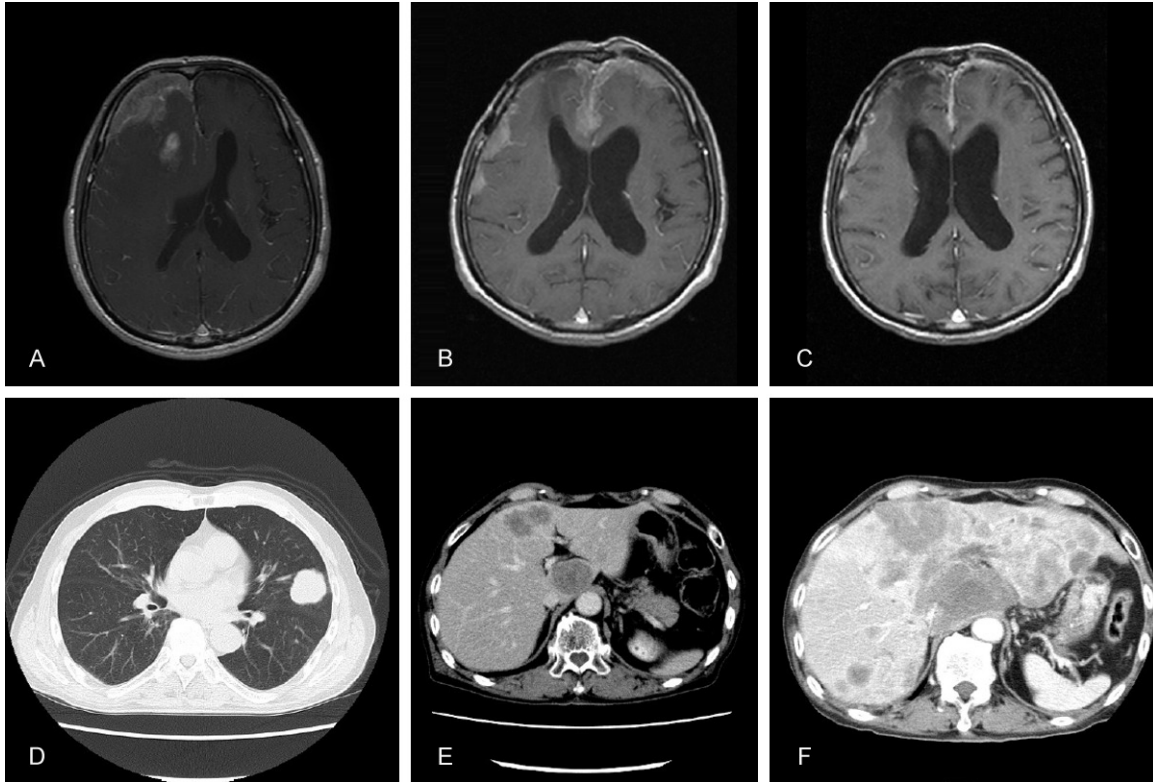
MRI T1-weighted images with Gd-enhancement. A: Pre-operative image. B: Post-operative, pre-chemotherapy image. C: Post-chemotherapy image. D: Chest CT image with enhancement at post removal of brain tumor. E: Abdominal CT image with enhancement at pre-chemotherapy. F: Abdominal CT image with enhancement at post-chemotherapy.
